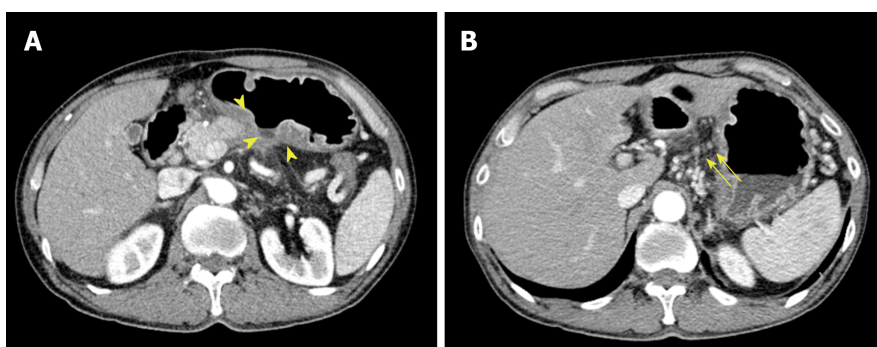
Follow-up contrast-enhanced abdominal computed tomography images. A: Previous mucormycosis lesion in the posterior wall of the lower body of the stomach showed much-improved state (yellow arrow head); B: Only small left gastric lymph nodes was observed (yellow arrow).
